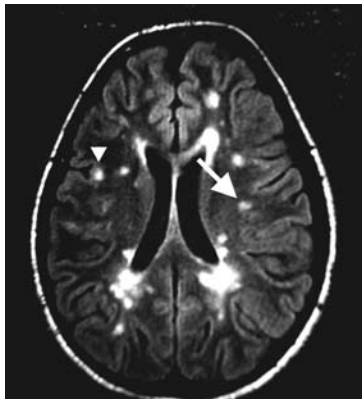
The axial view of brain MRI (FLAIR) showing the multiple high signal lesions in the paraventricular (long arrow) and juxtacortical area (arrowhead).
